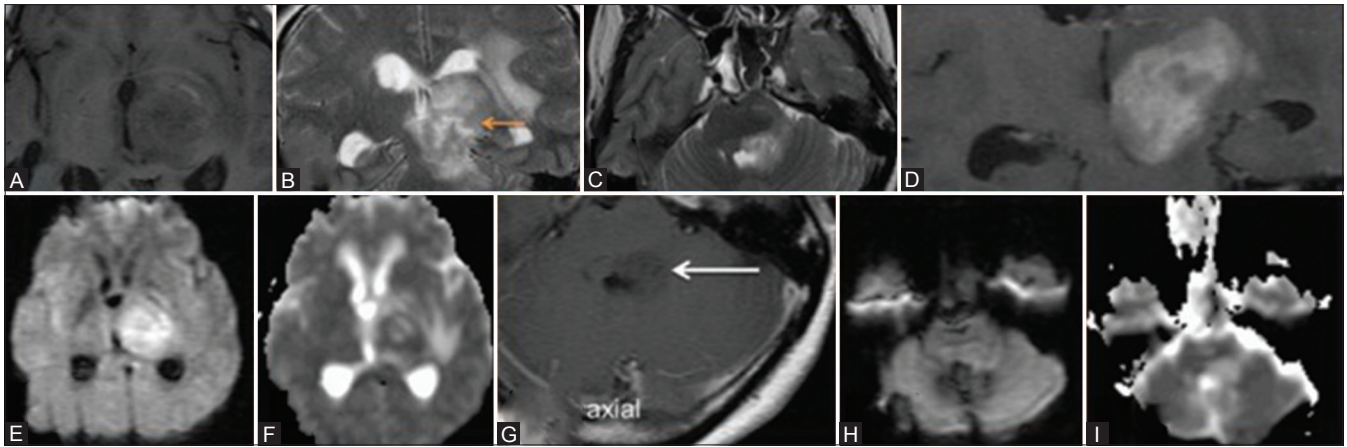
(A-I): History – A 52-year-old immunocompetent female presented with headache since one and half month; right hemiparesis with deviated angle of mouth to left side for 20 days. On MRI, there was a left thalamopeduncular lesion isointense on T1W (A), hyper intense on T2W (B) images with homogenous enhancement on post-contrast study (D) and restricted diffusion on diffusion weighted and apparent diffusion coefficient images (ADC) images (E, F). Another non-enhancing lesion noted in the left cerebellum (arrow) adjacent to fourth ventricle on post-contrast study (G). This was hyperintense on T2W (C), FLAIR (not shown in the figure), and showed no restricted diffusion on diffusion weighted and apparent diffusion coefficient images (H and I)
